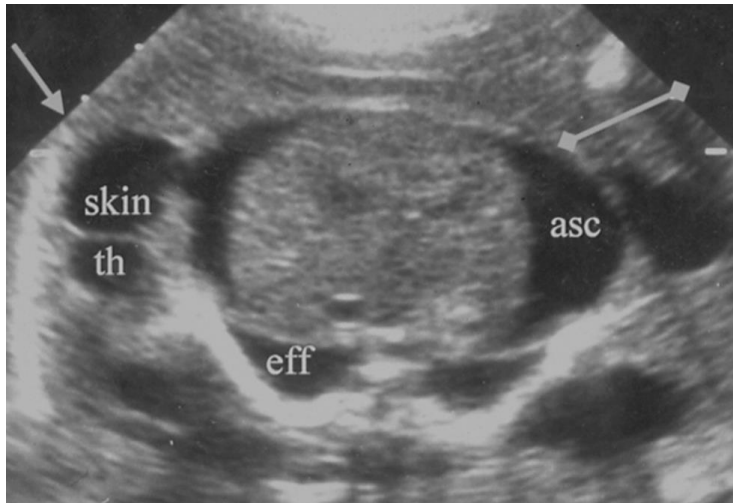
Fetal Hydrops. Ultrasound (Axial plane) Skin th = skin thickening, eff = pleural effusion, asc = ascites.
